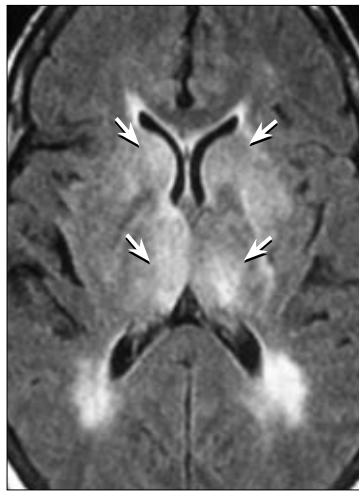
Axial FLAIR MR image shows bilateral hyperintense signal throughout the bilateral basal ganglia.
